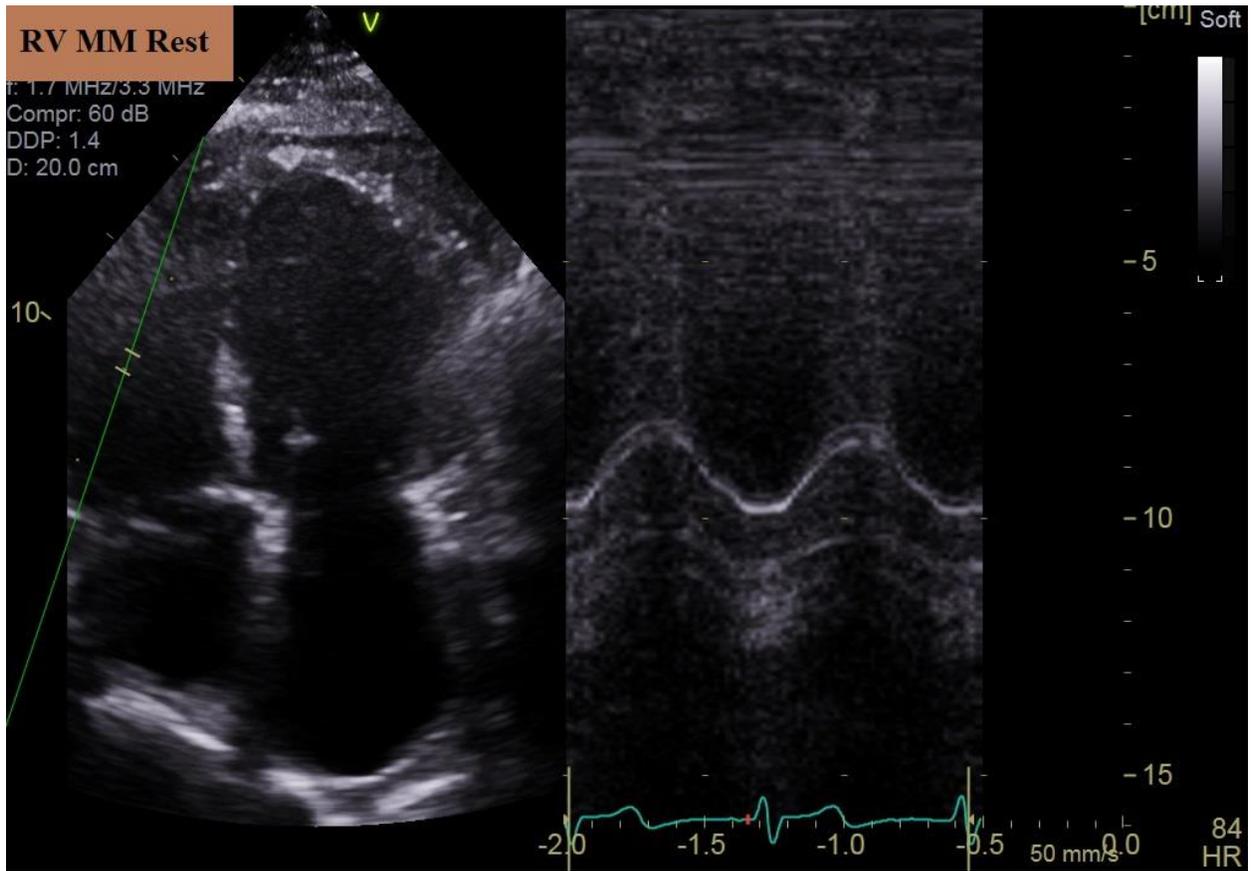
Trans-thoracic echocardiography, Right Ventricle M-mode at rest.
